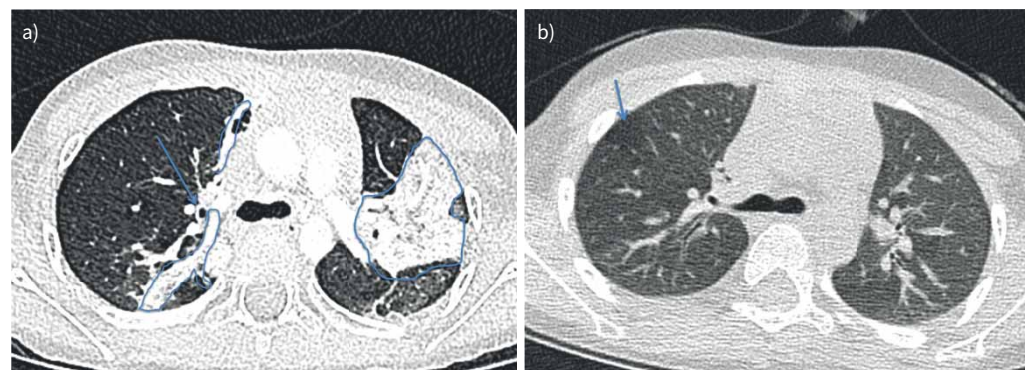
a) Initial computed tomography (CT), annotated; b) repeat CT.
